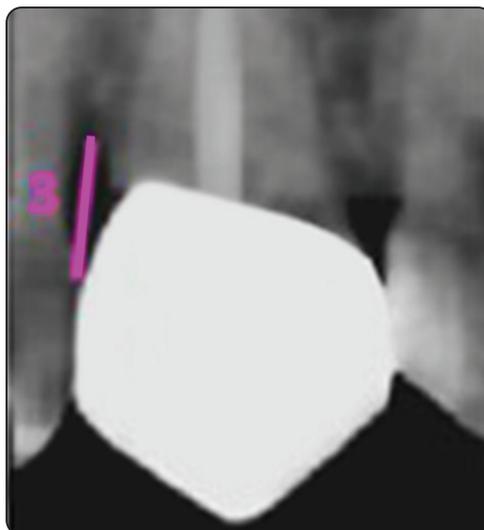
B- X-ray of first premolar with CS crown.
